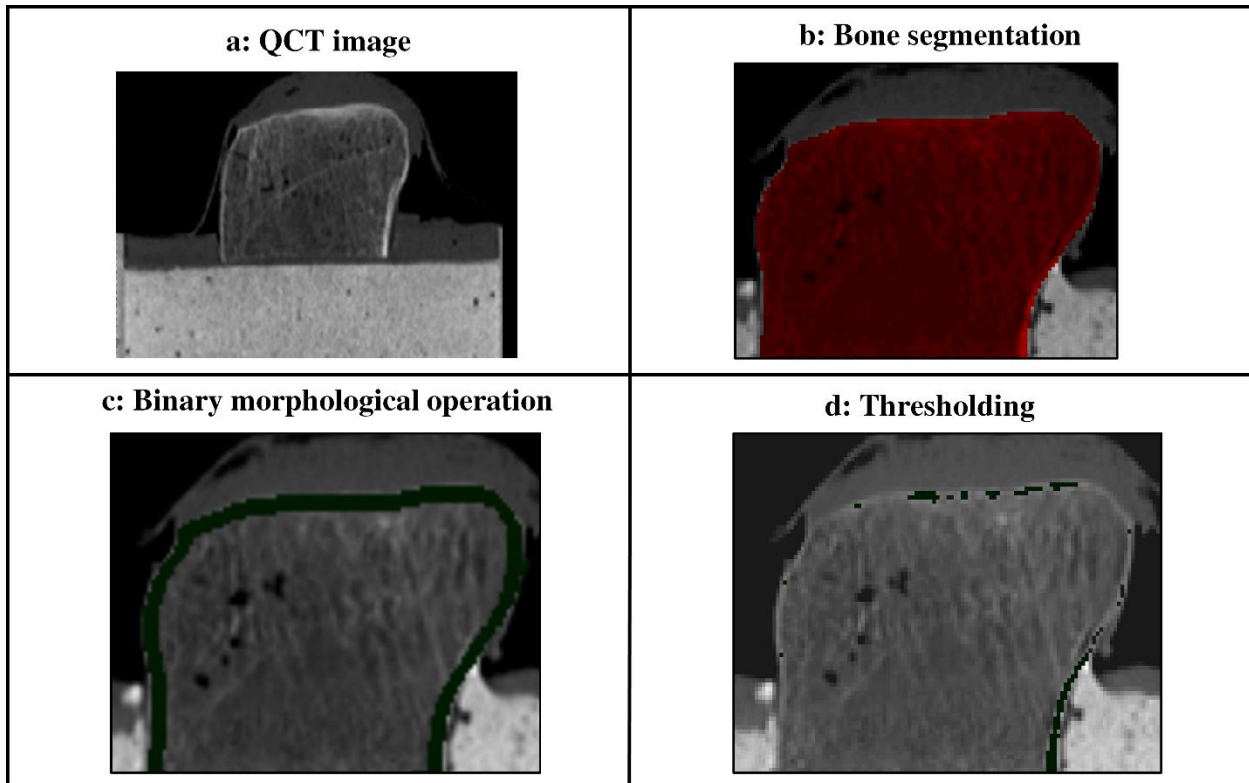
The methodological sequence for tissue separation using an image erosion technique. The CT image (a); was first segmented using the half maximum height method (HMH) and region growing algorithm (b). Binary morphological operations were then used to detect a temporary cortical region with the thickness of 3.5 mm (c); the cortical bone was then determined using the threshold of  $550 \text{ mg/cm}^3$  within the region of interest (d).
